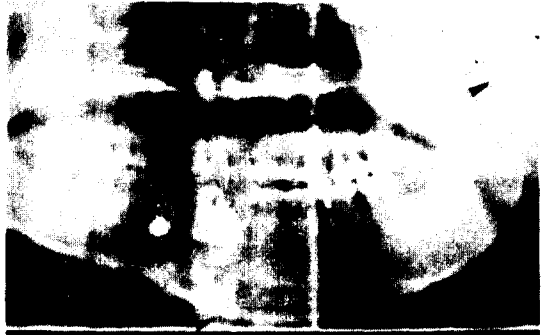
Preoperative panoramic radiograph of case 2. Note the elongated Condylar neck and the bowing at the inferior border of mandible.
